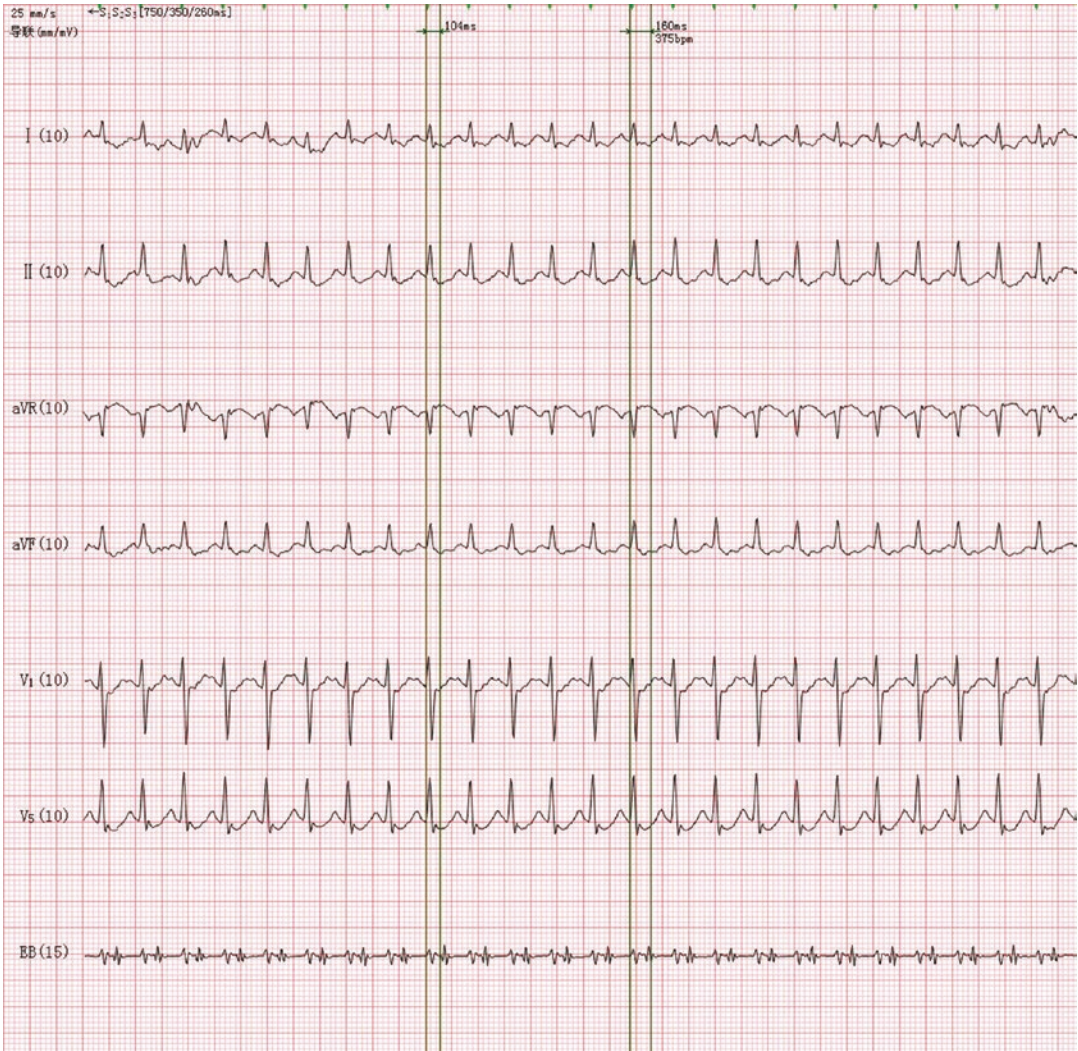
Atrioventricular reentrant tachycardia was diagnosed with transesophageal cardiac electrophysiological study. The RP interval was greater than 70 ms in lead esophageal, which was shorter than it in lead V1, indicating that impulse travel antegrade through atrioventricular
